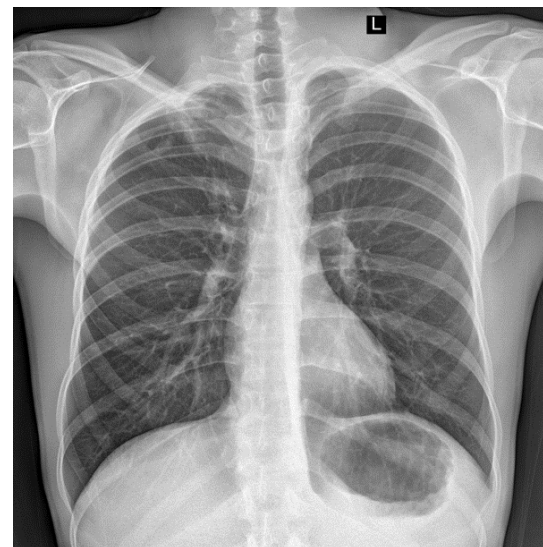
Chest X-ray: a suspicious infiltrate at the top of the right lung on the computed tomography scan has not been confirmed – no abnormalities in the lungs were found.
